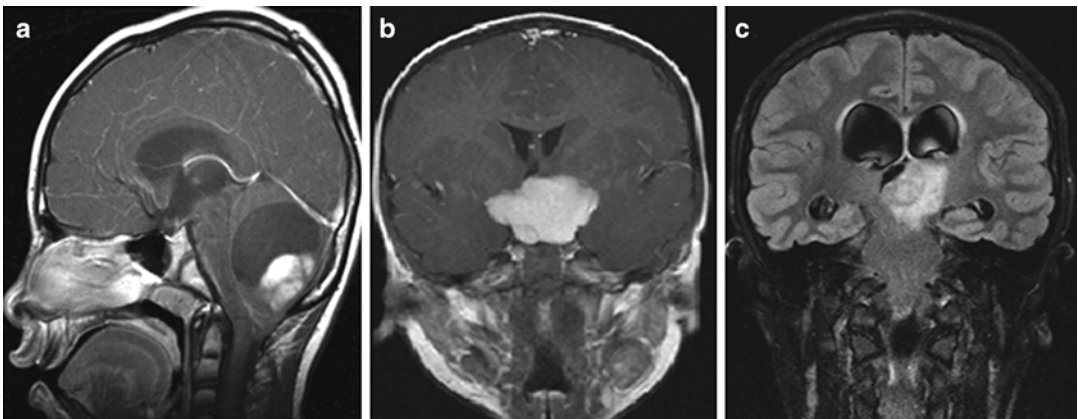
Magnetic resonance images of three different pediatric low-grade gliomas. (a) Cerebellar pilocytic astrocytoma (sagittal post-gadolinium sequence) with mural nodule and large cystic component. (b)
